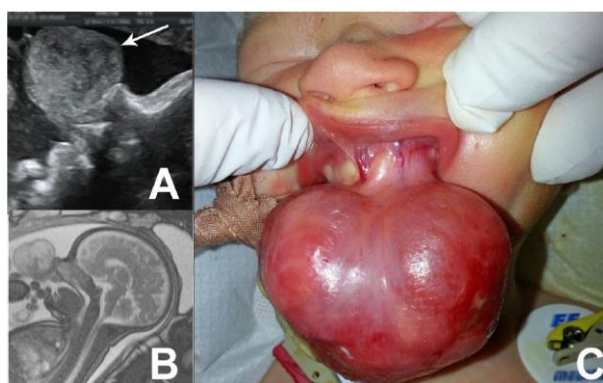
Prenatal Imaging (A-ultrasonography and B-fetal MRI) and postnatal aspects (C) of upper jaw CE
